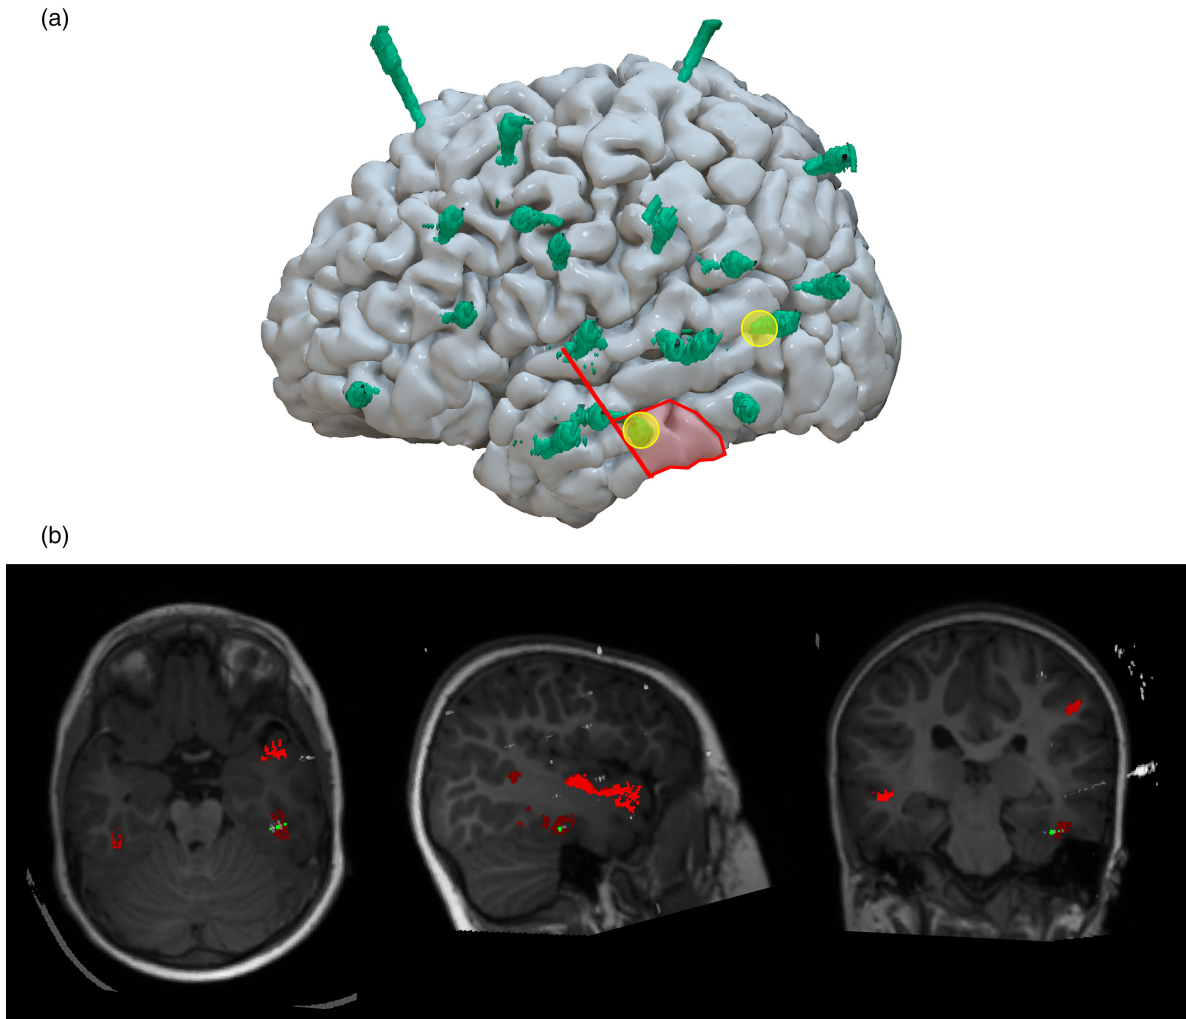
Case study no. 1. (a) 3D view of the cortical surface with the SEEG electrodes shown in green. Yellow identifies the additional electrodes implanted as part of the MAST trial. The red shaded area outlines the posteroinferior extension of a standard temporal lobectomy deemed necessary because of the additional electrode. (b) Axial, sagittal, and coronal views of the T1 magnetic resonance imaging scan with the MAST clusters visible in red. The additional basal temporal electrode contacts are highlighted in green. Abbreviations: MAST, MELD as an adjunct for SEEG trajectories; SEEG, stereoelectroencephalography.
